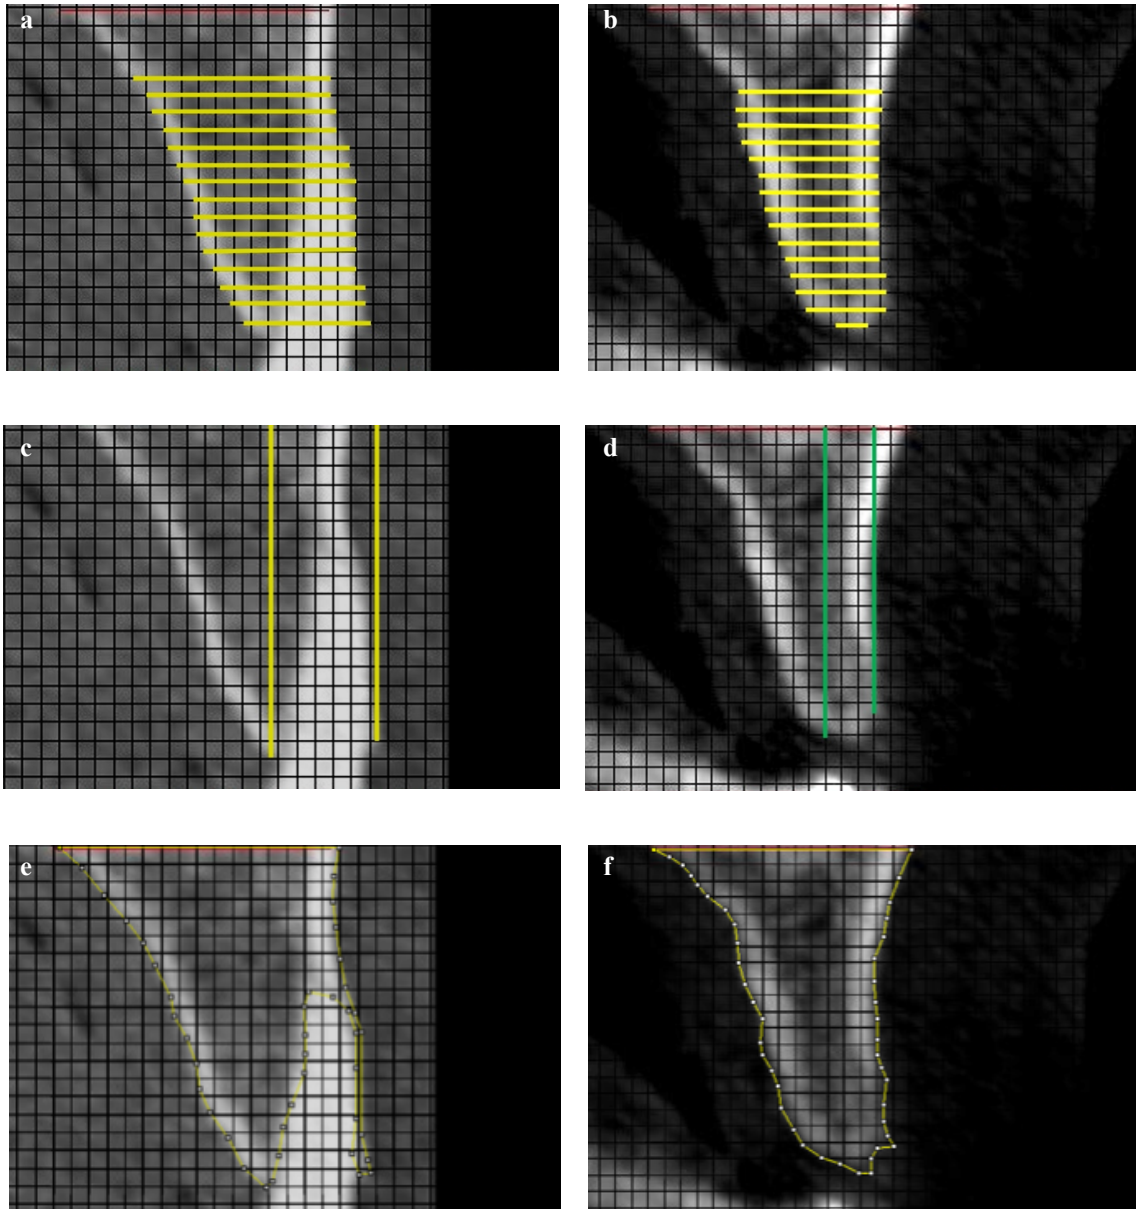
Radiographic evaluation protocol, hard tissue dimension changes in a control patient
